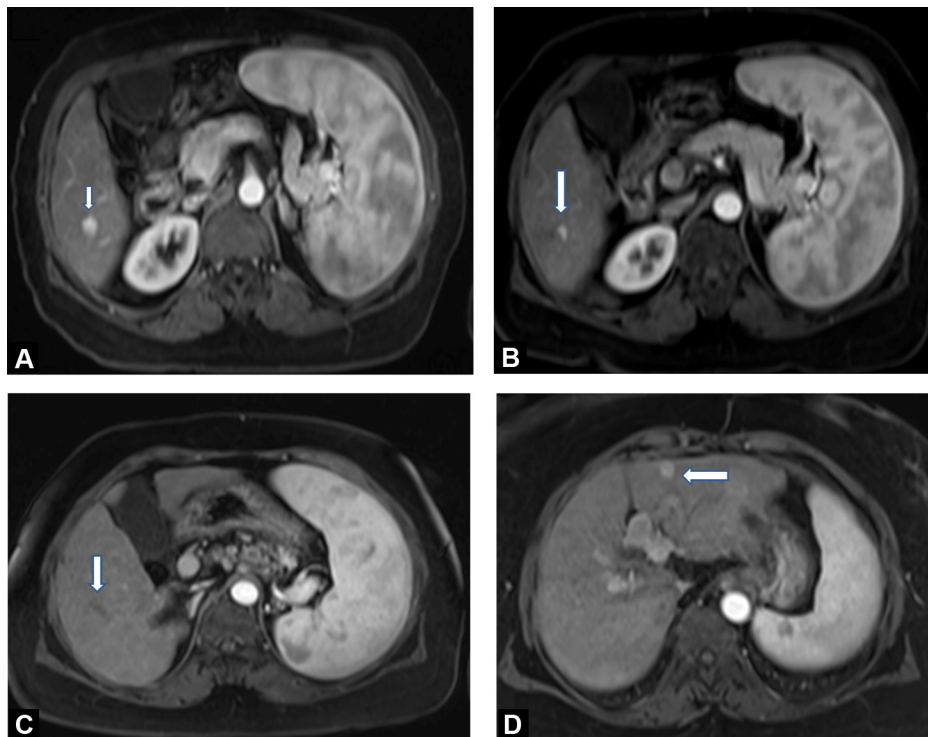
A 41-year-old woman with hepatitis C-related cirrhosis and hypervascular hepatocellular carcinoma (HCC) of 1.5 cm in segment 6 of the liver: A: MR image of the liver in the axial plane obtained during the arterial phase following intravenous administration of gadolinium chelate reveals hypervascular HCC nodule (arrow). The tumor was treated percutaneously using 2 mL of 40% acetic acid; B: four weeks after percutaneous acetic acid injection (PAAI), MR image of the liver in the axial plane obtained during the arterial phase following intravenous administration of gadolinium chelate shows a small, residual enhancing area (1×0.5 cm) in the treated HCC nodule suggestive of partial response. Repeat PAAI was performed; C: follow-up MRI at two years, shows reduction in size and absence of enhancement in the treated HCC during the arterial phase (arrow); D: however, a newly developed, subcapsular small HCC is detected in the left lobe of the liver (arrow), for which PAAI was subsequently performed and complete response was achieved.
